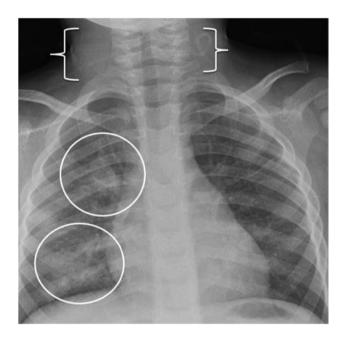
Anterior–posterior view chest radiograph showing patchy airspace disease more obvious on the right with cervical and supra-hilar lymphadenopathy.
